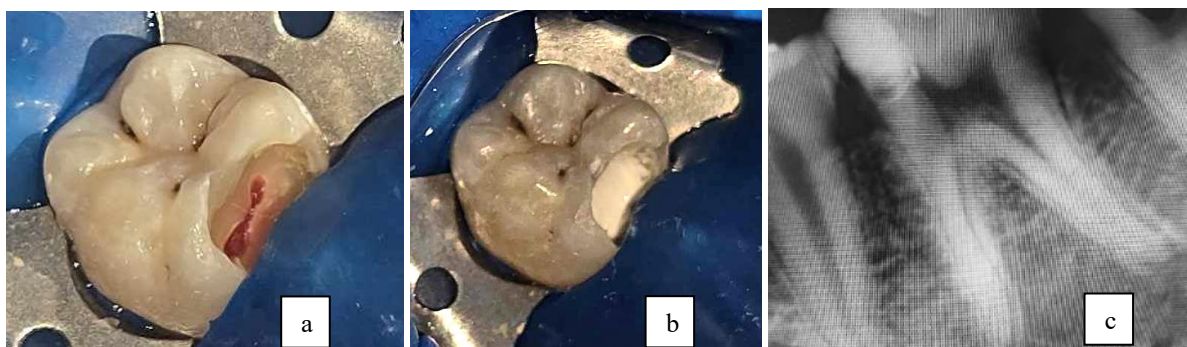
[a] curreting of the carious lesion and partial pulpotomy. [b] pulp capping with MTA. [c] post-operative radiograph
